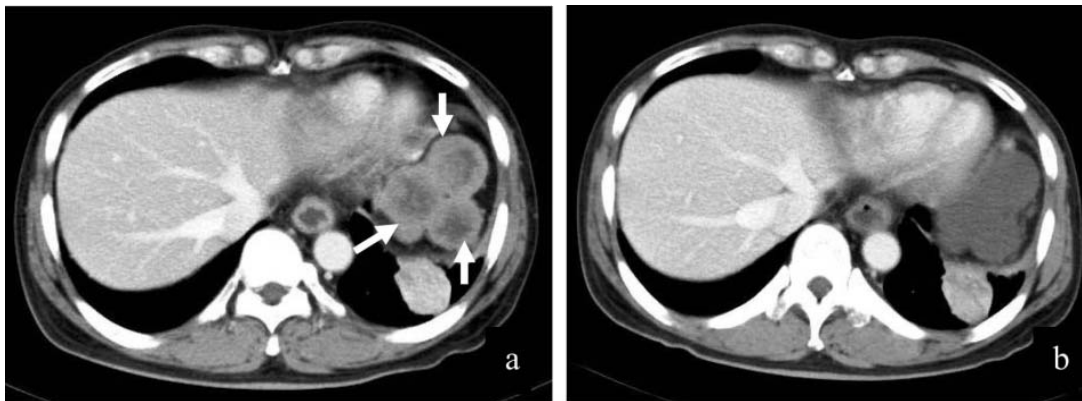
Contrast-enhanced CT scan of a 48-year-old male who had multiple intraabdominal metastatic GISTs, demonstrated three lesions with mural nodules (arrow) on pretreatment scan (a). Complete disappear of all solid nodules in these lesions was noted after 1 month of imatinib treatment (b).
